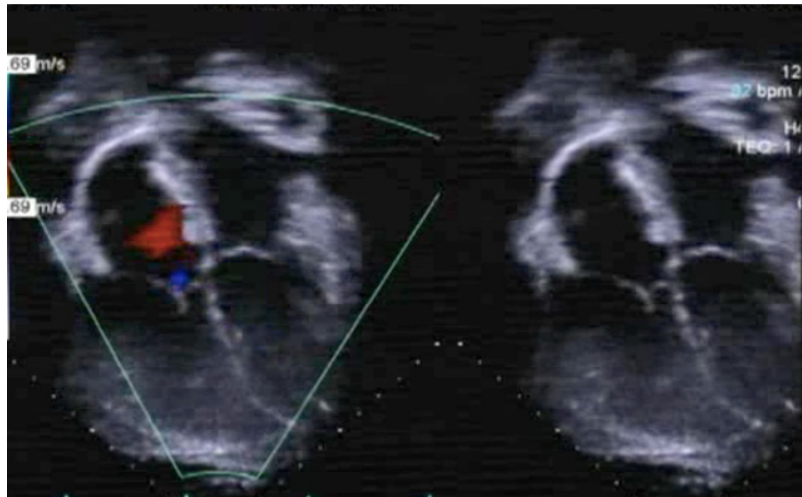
Transthoracic 2d echo with color (1 year and 9 months post closure), 4 chamber view showing the device in place at the interatrial defect with left to right shunt at the fenestration
